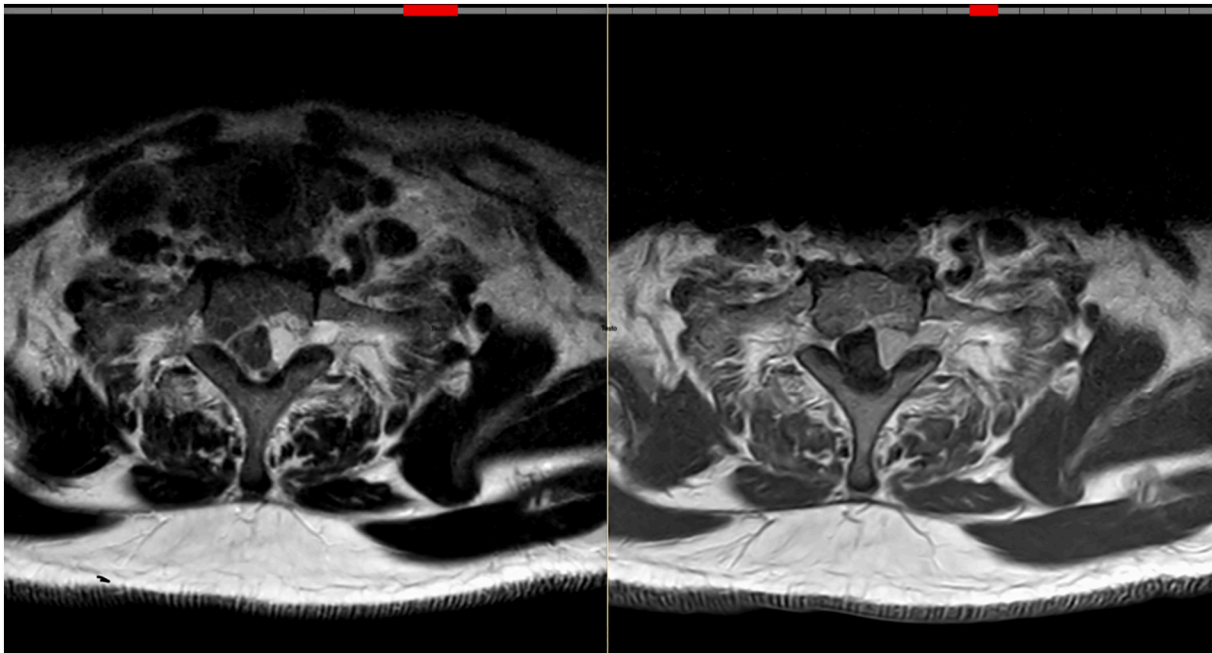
MRI in transverse projection. The lesion appears substantially homogeneous, slightly hyperintense in the T2-weighted sequence, isohypointense in the T1-weighted sequence and shows homogeneous enhancement after intravenous contrast injection. It has the classic look of a dumbbell-shaped spinal neuroma.
